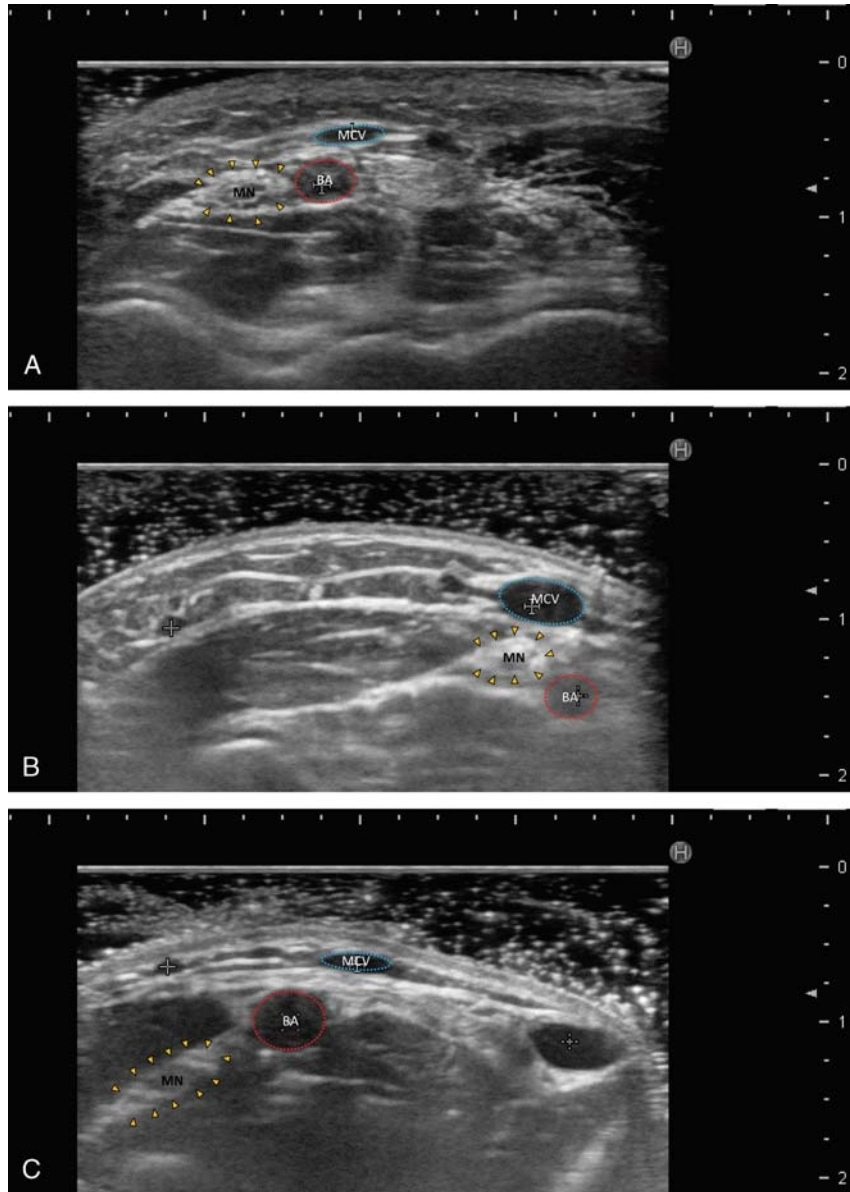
Ultrasound images showing positional relationships between the median nerve and brachial artery. A, The median nerve and brachial artery were located at the same distance from the epidermis. B, The median nerve was located in a more superficial layer than the brachial artery. C, The median nerve was located in a deeper layer than the brachial artery. BA, brachial artery; MCV, median cubital vein; MN, median nerve.
